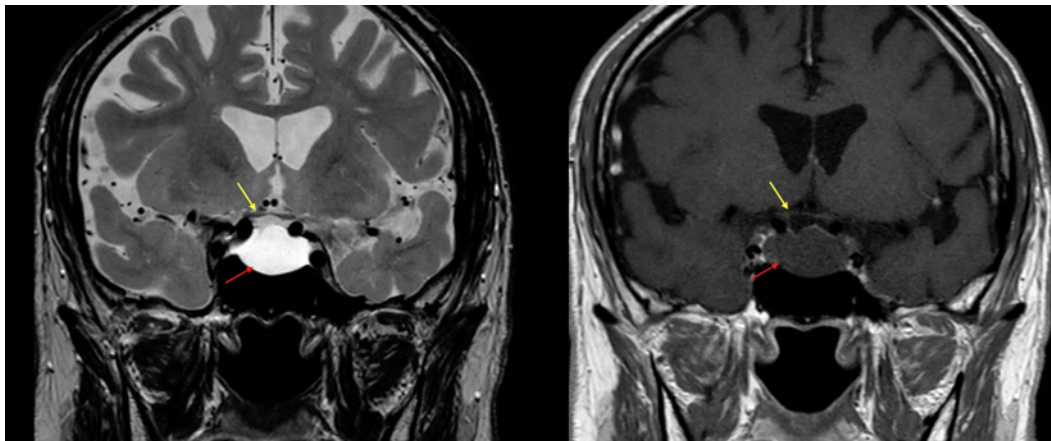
MRI of the sella (T2 top and T1 post-contrast bottom) indicating atrophy of the optic chiasm (yellow arrow) and a T1 hypointense and T2 hyperintense nonenhancing (cystic) sellar/suprasellar mass (red arrow).
